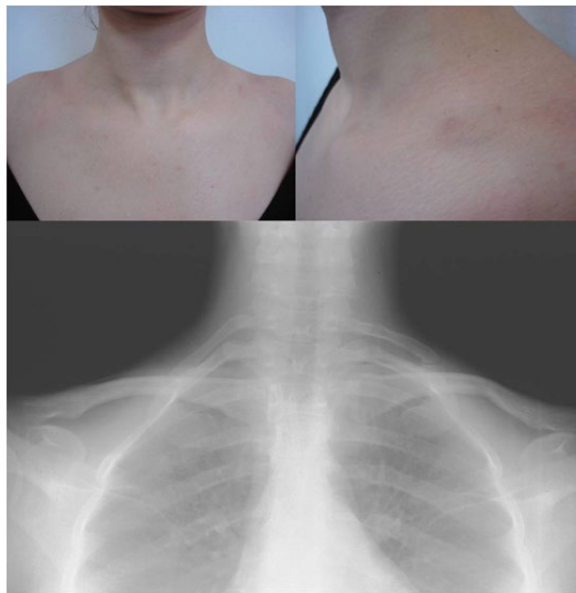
A 22-year-old woman complained for a painless bony lump over the medial border of the left clavicle. Physical examination revealed brachial plexus nerve compression symptoms that were more expressed in the left side, though they were also present on the right side too. The radiograph showed fully developed symmetrical cervical ribs originating from the seventh cervical vertebra. A joint process of the first rib at the place of insertion of the cervical rib was clearly evident on the left side. The cervical column was not abnormally shaped.
